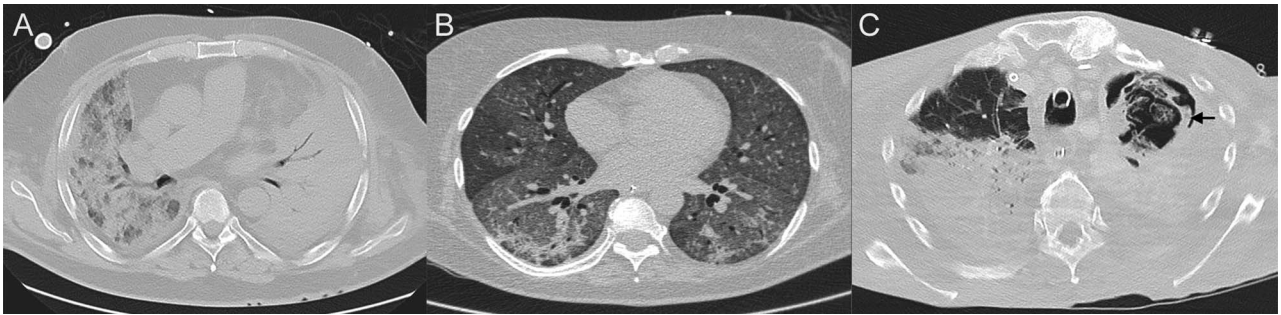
Axial computed tomography images without contrast enhancement of 3 different subjects affected by community-acquired pneumonia (A), pneumocystis pneumonia (B), and aspergillosis, indicated by an arrow (C), respectively.
